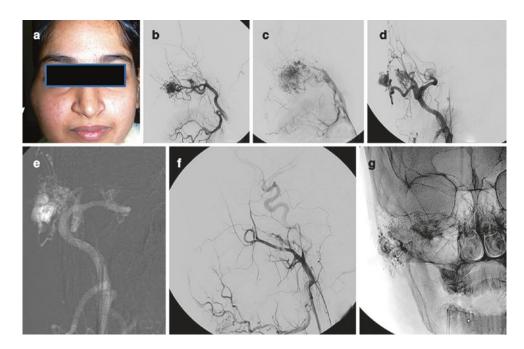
Eighteen Y/F with swelling right cheek which is pulsatile. (a) Clinical photograph showing right zygomatic arteriovenous malformation. Transarterial Glue (NBCA) embolisation was performed through two arterial feeders leading to complete cure. (b, c, d) Catheter angiography showing the arterial feeders, the nidus and the draining veins. (e) Arterial roadmap showing distal microcatheter position. (f) Post Embolization angiogram showing complete obliteration of the AVM nidus. (g) Plain radiograph showing glue cast
